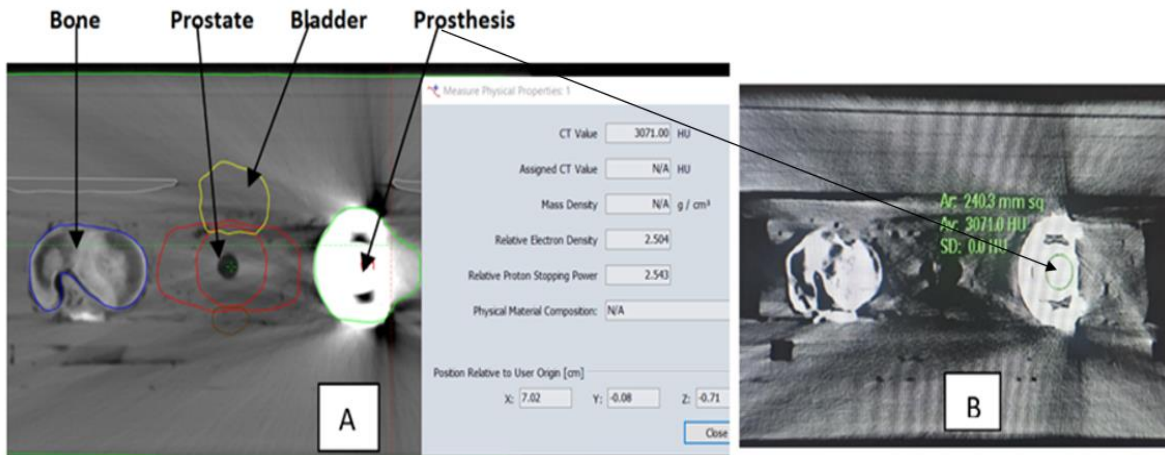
9 : Relative electron density obtained from (A) TPS CT scan dataset and (B) the O-MAR CT data from the CT scanner.
